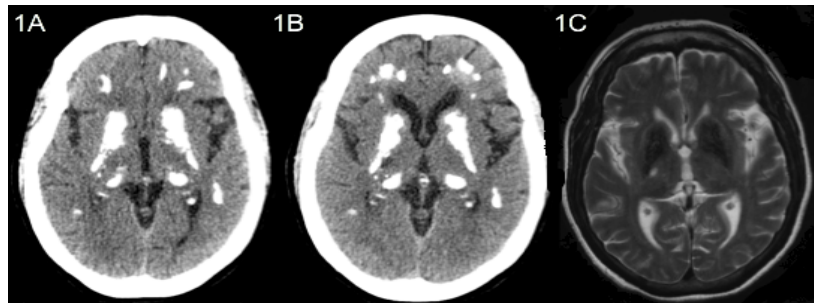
Serial CT and MRI. First head CT (A) revealed diffuse calcifications in basal ganglia, cerebellum and periventricular white matter. Following CT (B) showed hypodensity on the right thalamus. Subsequent T2 weighted MRI (C) demonstrated lacunar hypointensity on the right thalamus.
